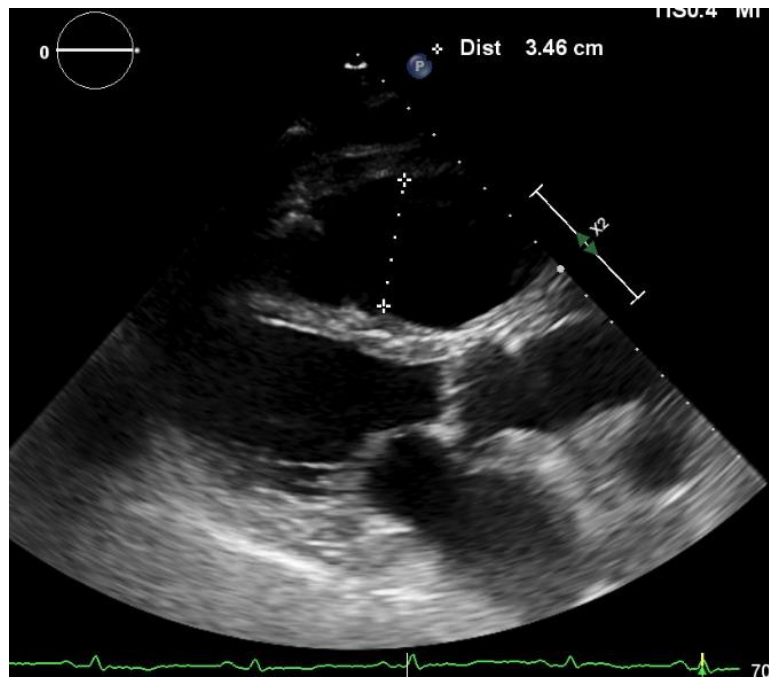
Echocardiography parasternal long axis view showing Right Ventricular outflow tract dilatation at 34.6mm.
